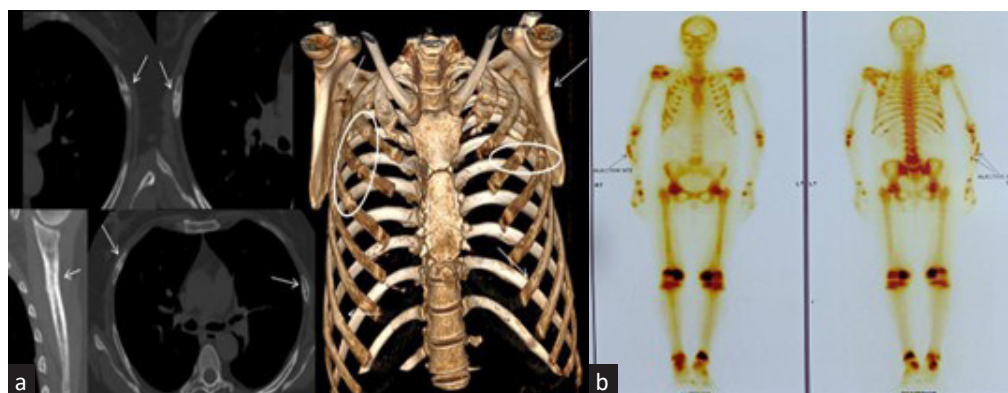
(a) Computed tomography thorax imaging and 3D reconstruction showing pseudofractures or Milkman's fractures of multiple ribs bilaterally and medial borders of both scapulae are shown by the white arrows and white circles respectively. (b) Tc 99 bone scan showing increased uptake in the same areas.
